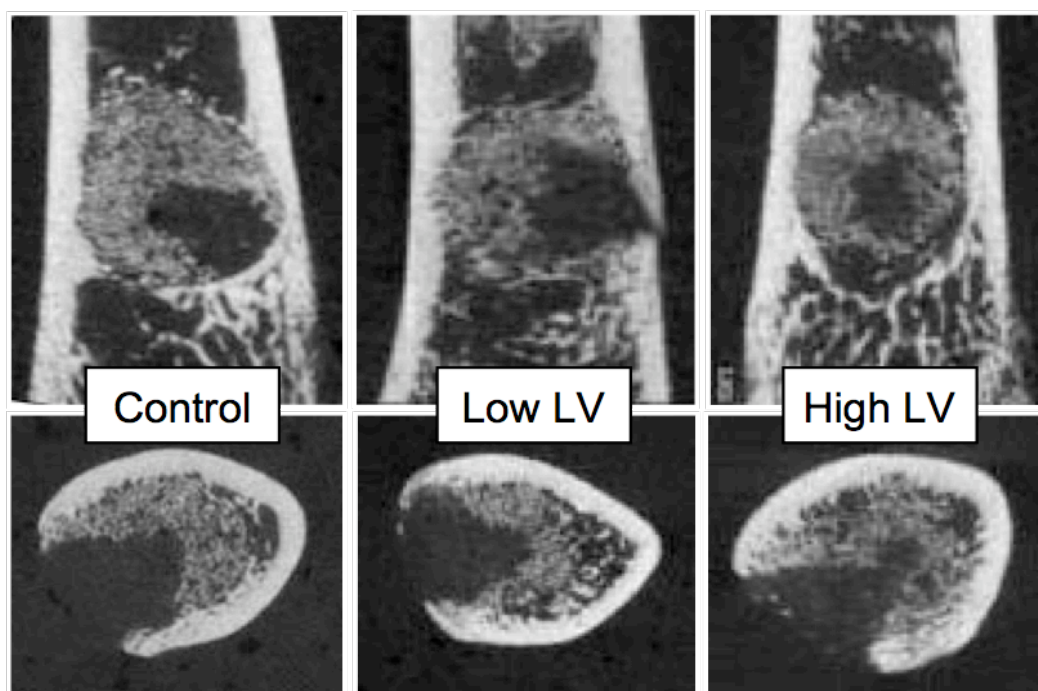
Representative sagittal (top) and coronal (bottom) μ CT images of femoral plug defects filled with PUR-LV scaffolds after 4 weeks. Mineralized bone formation was slightly, but not significantly, enhanced with the high LV treatment.
